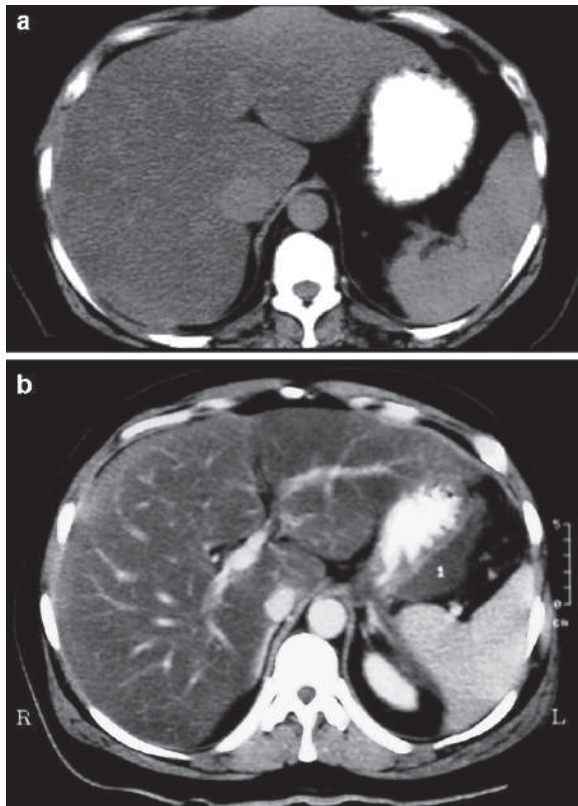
Axial precontrast (a) and postcontrast (b) abdominal CT images show diffuse hepatic steatosis. Notice the density of the liver compared to the spleen in pre- and postcontrast images
